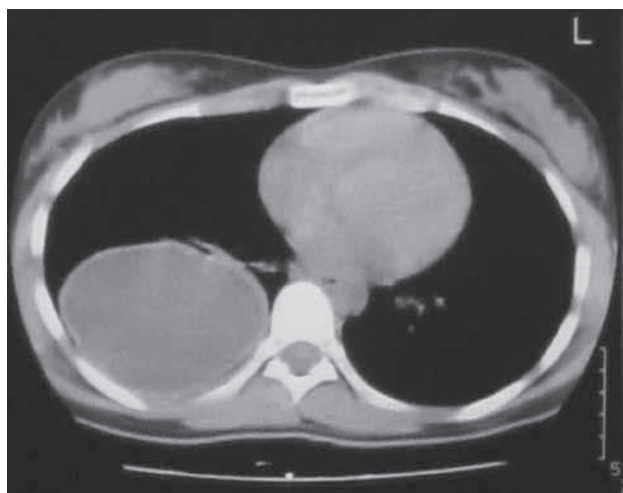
Computed tomography (CT) of the thorax in a 16-year-old female, showing the presence of a right sided mass, with a diameter of 9 cm and the morphological characteristics of a cyst.
